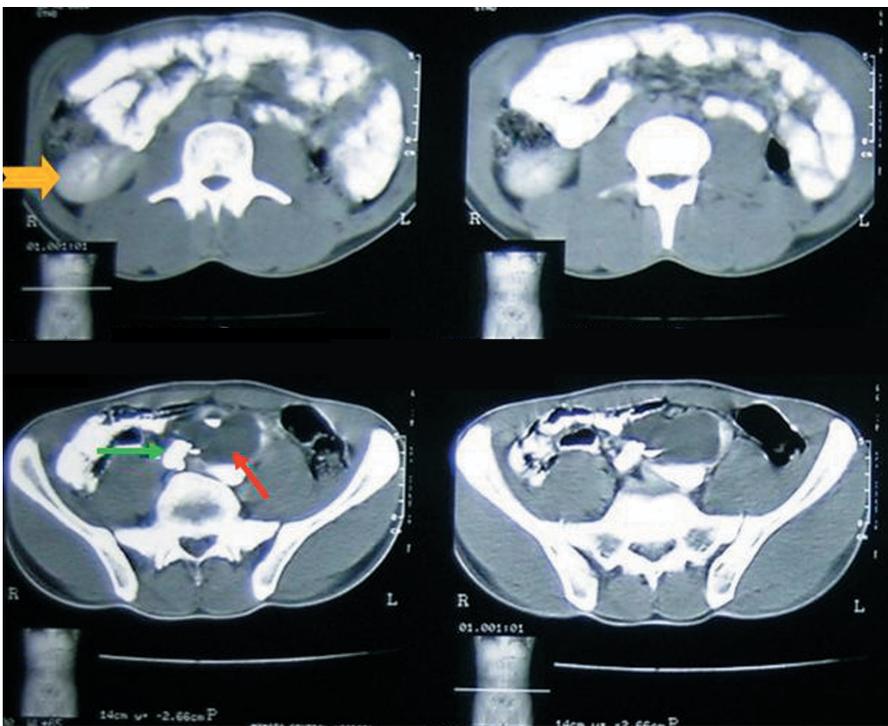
Computed tomography scan showing the right kidney in the normal location (orange arrow). A hydronephrotic left kidney (red arrow) is seen in front of the sacrum, with a calculus in the left renal pelvis (green arrow).
